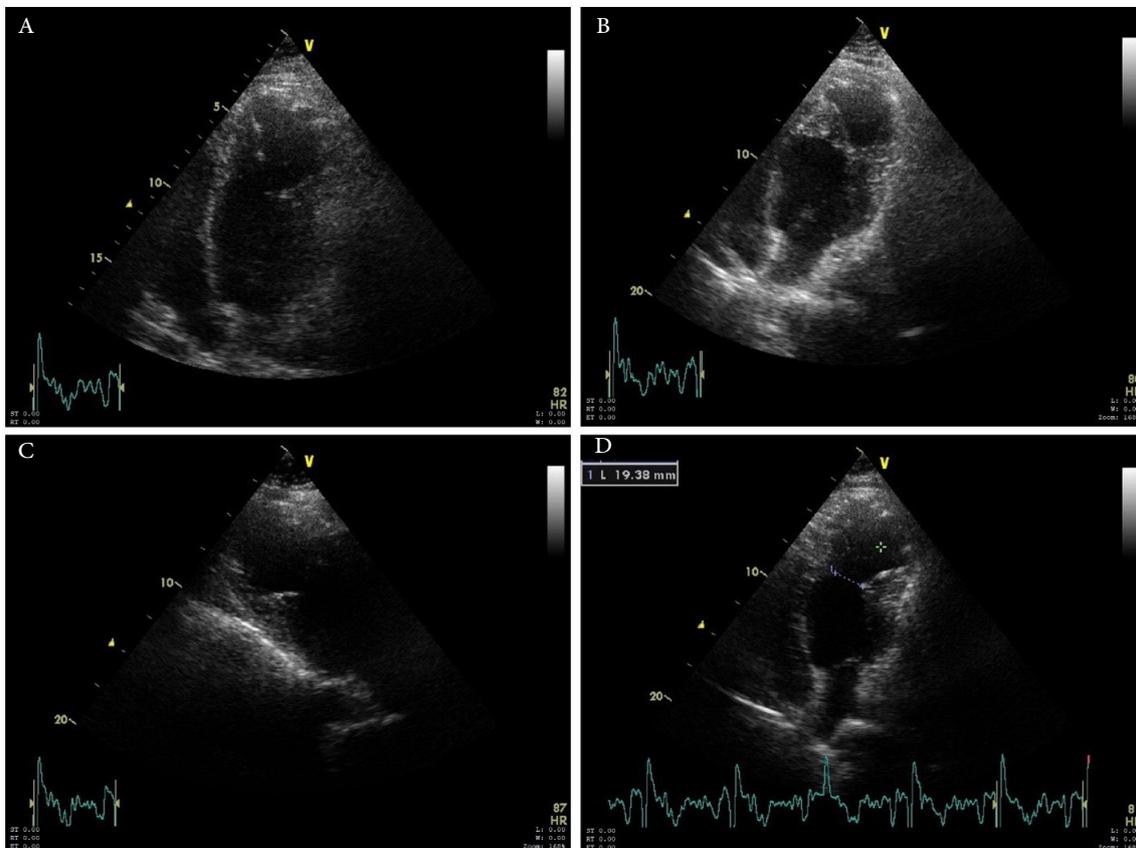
Apical chamber views. A, B, D represented an apical four chamber views and figure C revealed apical long axis view.
